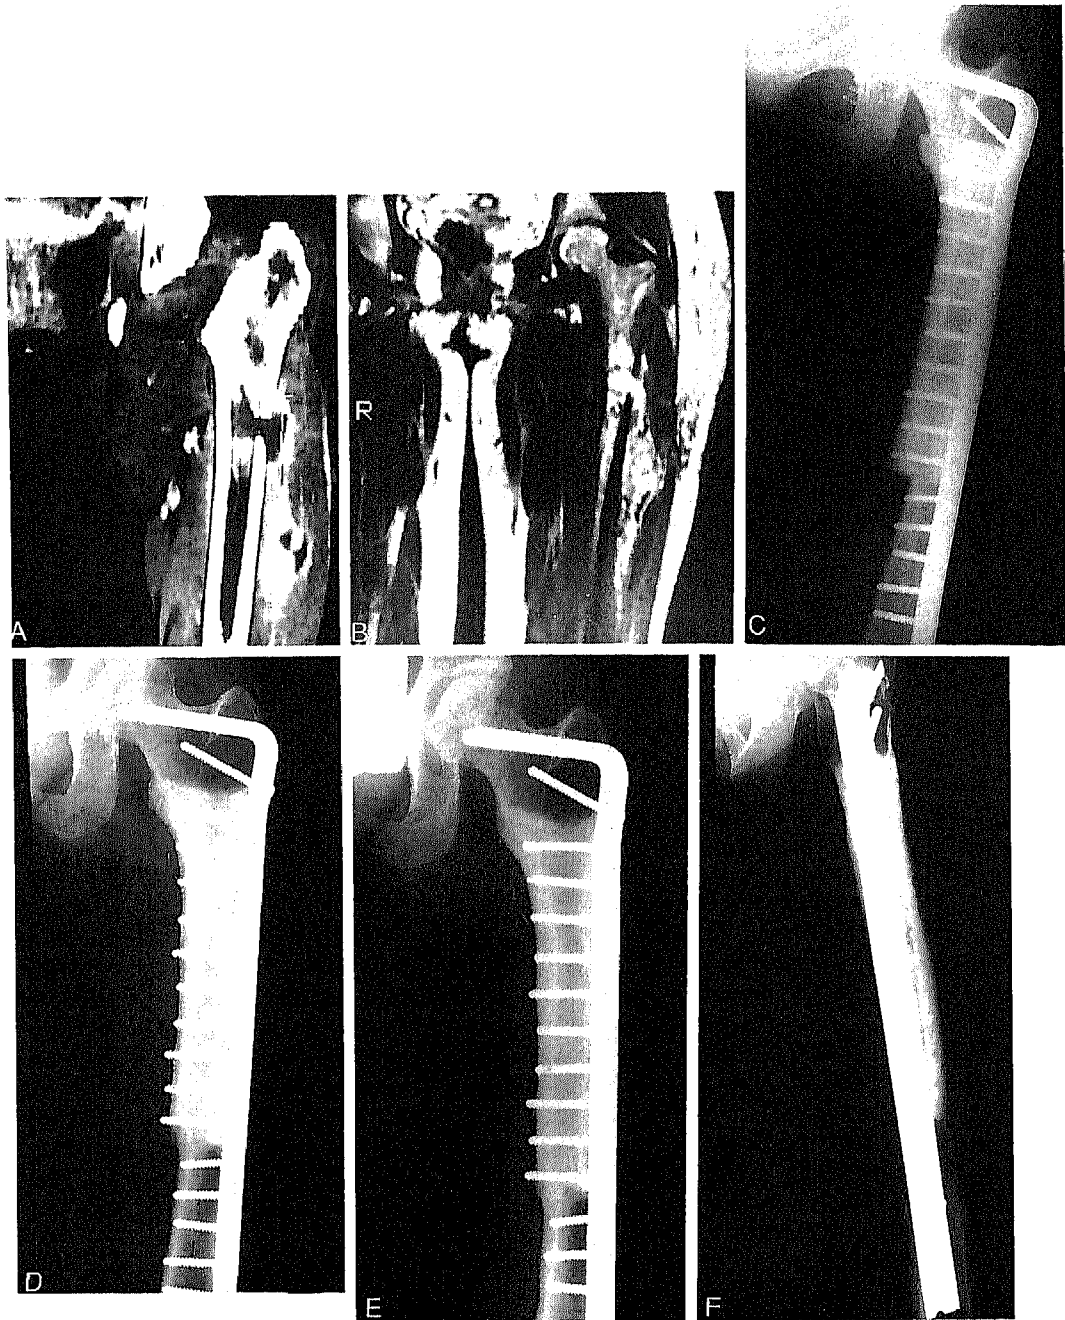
Soft tissue sarcoma of the proximal thigh involving the femoral canal. (A) T2 weighted magnetic resonance image; (B) computed tomography scan reconstruction; anteroposterior radiograph of intercalary reconstruction of the proximal femur at (C) the start of pulsing electromagnetic field stimulation (cortico-cortical contact type), and (D) optimal fusion after 6 months of stimulation; (E) anteroposterior and (F) lateral views at 18 month followup.
